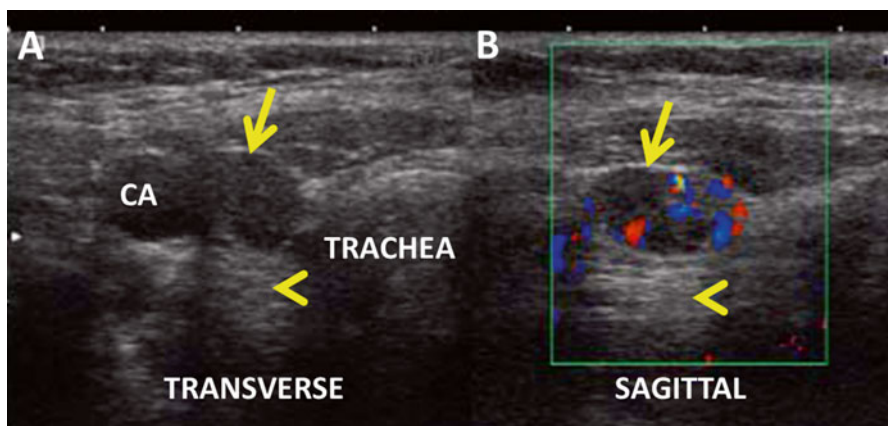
Cervical node ultrasound. A 1.5×0.8×1 cm node (*arrow*) is located inferior to the thyroid in the right thyroid bed, cervical node level VI, between the carotid artery (CA) and the trachea. The node is partially cystic with post-cyst enhancement (*arrowhead*) and peripheral vascular flow in the solid component of the node. (a) Node transverse view. (b) Node sagittal view with Doppler analysis
